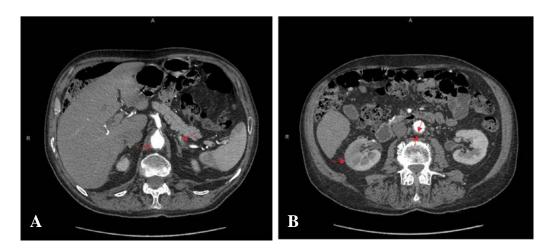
Computed tomography (CT) of the patient's abdomen at diagnosis. A, Segmental mural thickening of the splenic artery with significant narrowing of the lumen and aortitis of the abdominal aorta at the level of the celiac trunk is shown (arrows), with incomplete enhancement of splenic sinusoids during the arterial phase. B, Wall thickening of the infrarenal abdominal aorta on arterial phase imaging and ischemia of right renal parenchyma (arrows) was also demonstrated on CT.
